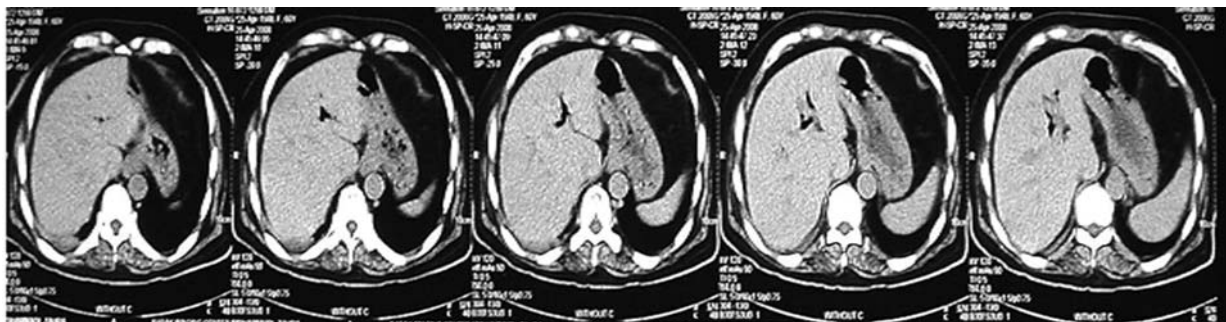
An abdominal CT scan showing pneumobilia.
